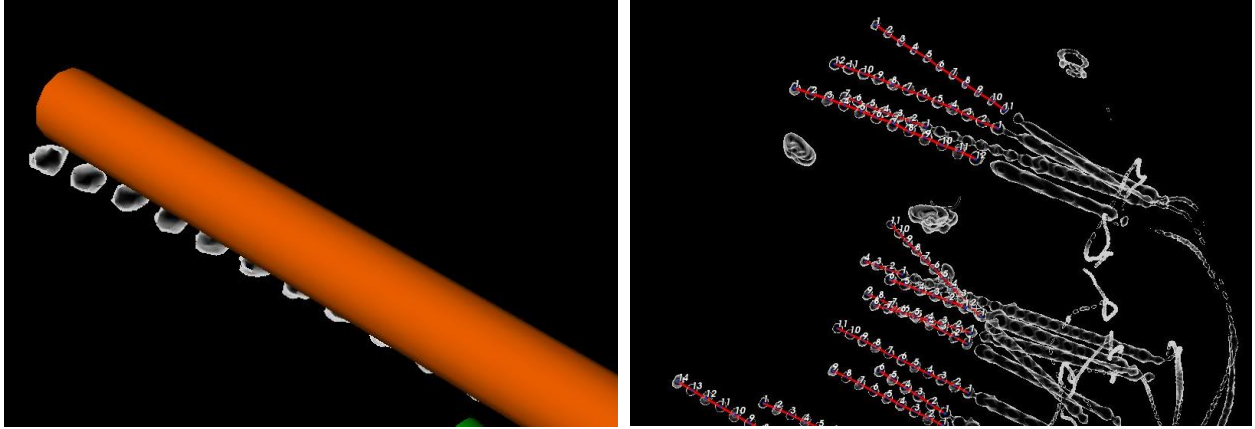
Left: upon registration, the user can compare the surgical plan referred to MR2c with the real outcome (using our segmentation method on the postoperative CT). Right: contact segmentation tool.
